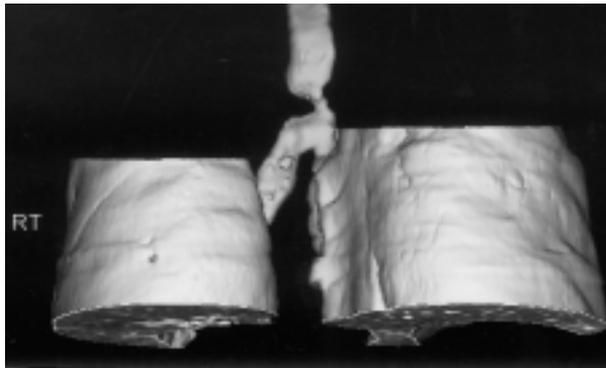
Three-dimensional computed tomography shows narrowing of the lower trachea.
